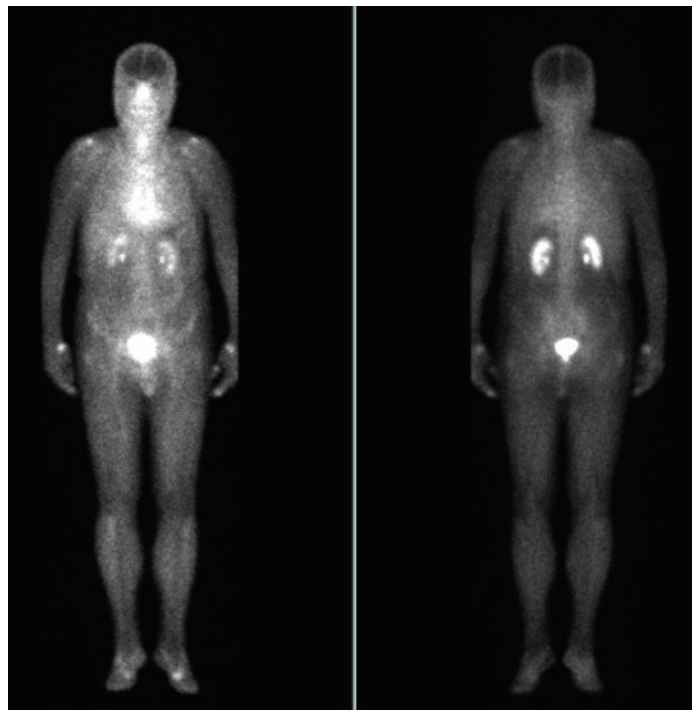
Previous scintigraphic examination of the patient one year before this scan and Bicalutamide treatment showed no sign of hyperemia in these areas.
